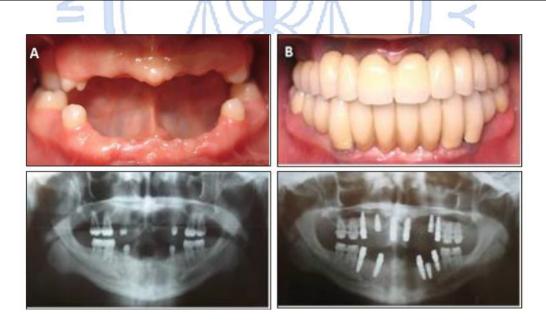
(a)Patient's occlusion before treatment (b)Definitive cement retained restorations in place(c)preoperative panoramic radiograph (d) postoperative panoramic radiograph of osseointigrated implants.
